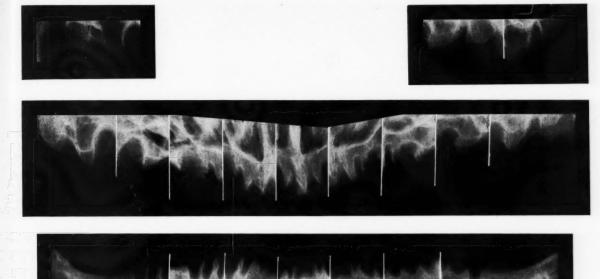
I A-Roentgenographic evidence of case without surgery.
